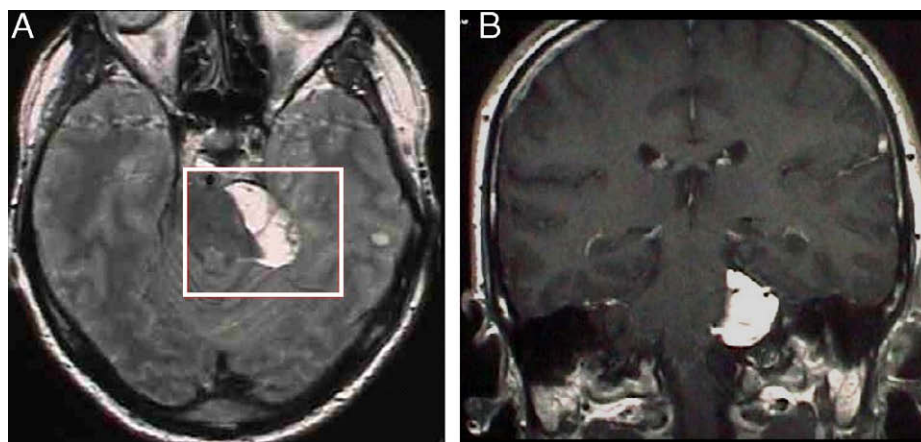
(A) Pre-operative axial and (B) coronal T1-weighted MRIs showing (in the white box) a cerebellopontine angle lipoma compressing the brainstem at the level of the incisura, with the trigeminal root pushed upward and the peculiar vascular supply of the brainstem with small arteries trespassing the lipoma from the posterior cerebral artery P1 tract to the brainstem.
